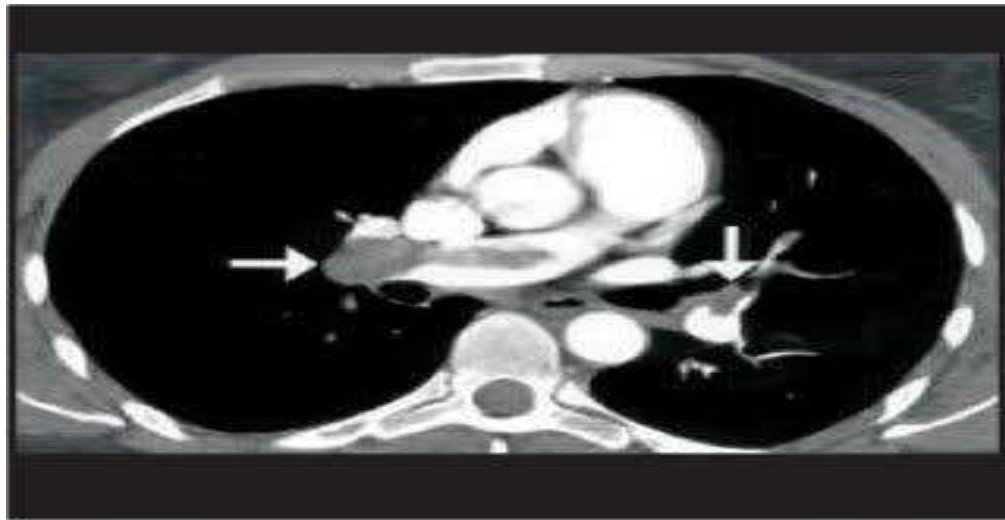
Acute pulmonary thromboembolism in 49-year old woman. Spiral CT image performed on multidetector CT reveals filling defects in the right main and interlobar pulmonary arteries and in the left lower lobe pulmonary artery with extension into the lingular artery (arrows).
